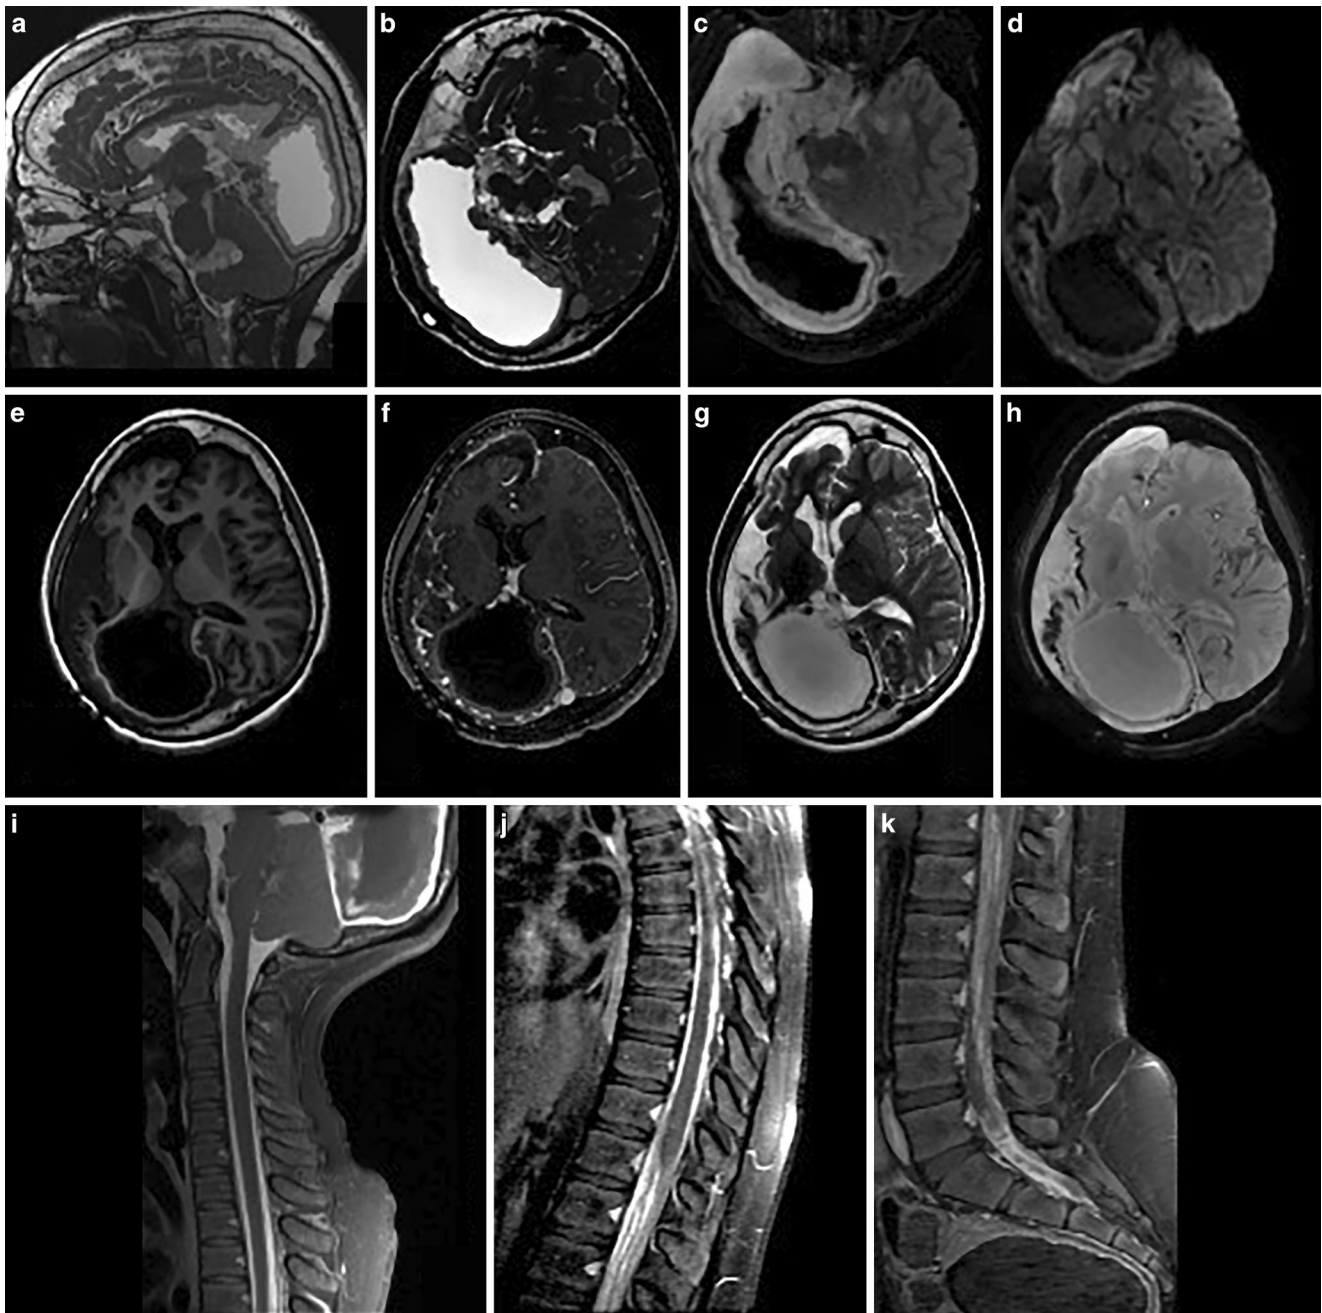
MRI sagittal CISS (a) and axial CISS (b), FLAIR (c), DWI (d), T1WI (e), CE T1WI (f), T2WI (g) and PD (h) images show clearly a well-defined tissue in the subarachnoid spaces, most in the right side of the brain, and also on the ependymal surfaces of the ventricular walls, especially the right lateral ventricle. FLAIR images show the enlargement of the subarachnoid spaces in the right hemisphere with hyperintensity compared to the CSF due to the tissue and hyperproteic fluid. There is also a thickening of the ventricular walls. Sagittal post-contrast T1WI (i–k) shows diffuse thick leptomeningeal enhancement obliterating the subarachnoid spaces in the spine, with the enhancement of spinal nerves. Meningeal enhancement and multifocal nodular thickenings are related to DL-GNT
